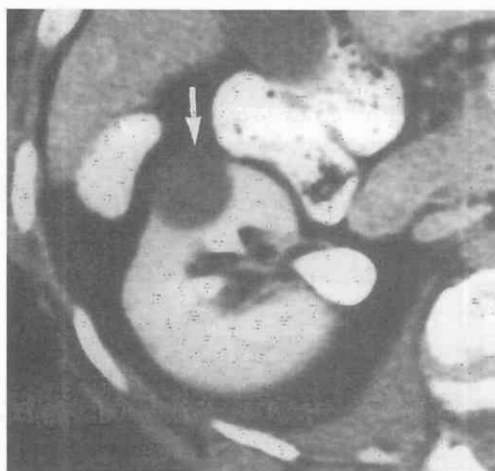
Simple renal cyst. Lesion (arrow) has attenuation value of 9 HU and was detected during survey CT scan performed only with intravenous contrast enhancement. Even though an unenhanced scan is unavailable, the diagnosis of a cyst can be made with confidence because of the low-attenuation value, smooth rounded shape, sharp margination, and demarcation from surrounding renal parenchyma and thin wall where the lesion projects beyond the renal outline.
